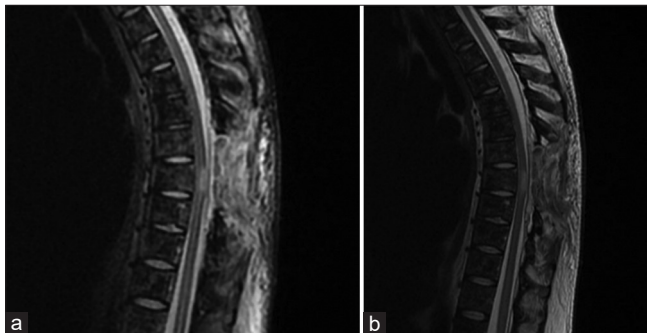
Postoperative sagittal thoracic spine MRI sequences showed a complete endospinal removal of the lesion images on STIR (a) and T2 sequences (b).
